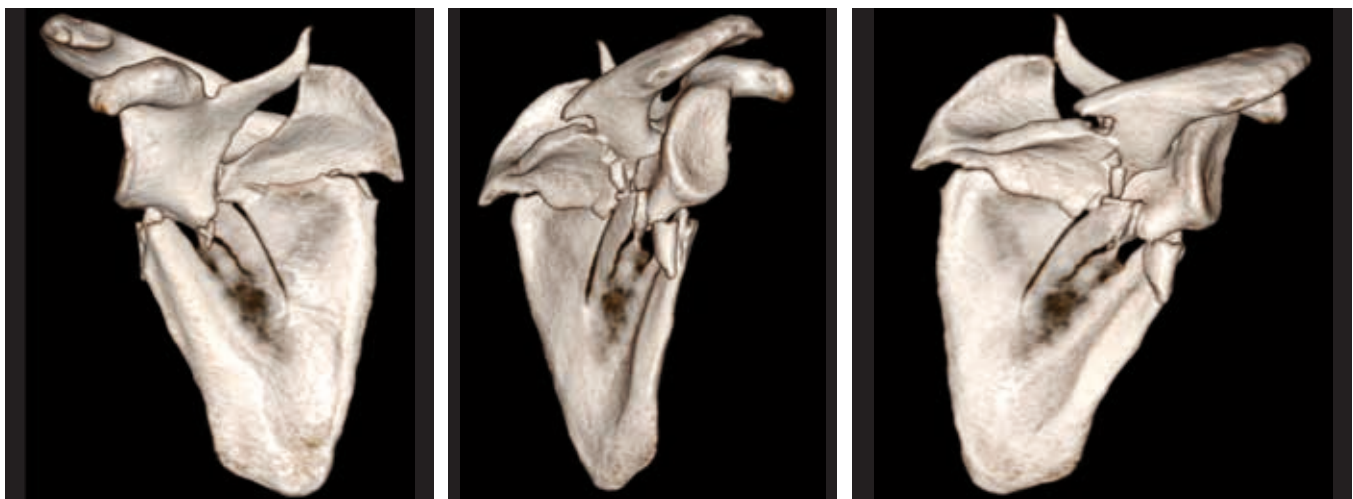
Internal fixation of a comminuted extra-articular fracture of the scapula – 3D CT reconstruction.
